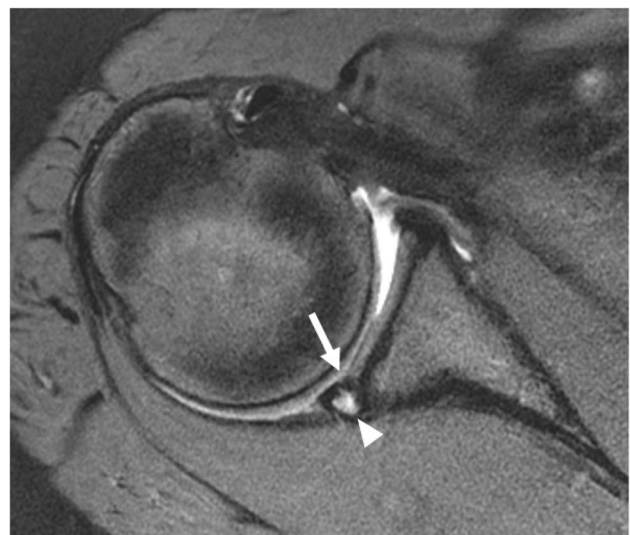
Axial T2 fat-saturated MR image demonstrates posterior decentering of the humeral head relative to the glenoid, subtle incomplete tear (“marginal crack”) of the posterior chondrolabral junction (arrow), and a cyst-like fluid collection between the glenoid and deep labrum (arrowhead) consistent with Kim’s lesion
